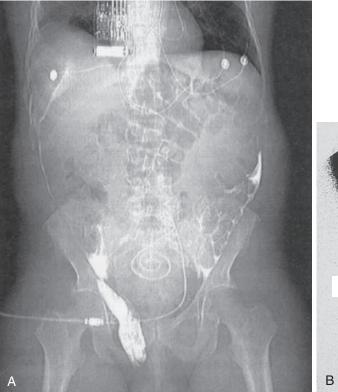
Inguinal hernia during peritoneal dialysis. (A) CT scan after intraperitoneal injection of contrast material in a male patient showing dialysate flowing into a right inguinal hernia. (A from reference 43.) (B) Peritoneal scintigram of a male patient on peritoneal dialysis showing bilateral inguinal hernias. The left hernia extends into the scrotum; the right hernia is less extensive.
